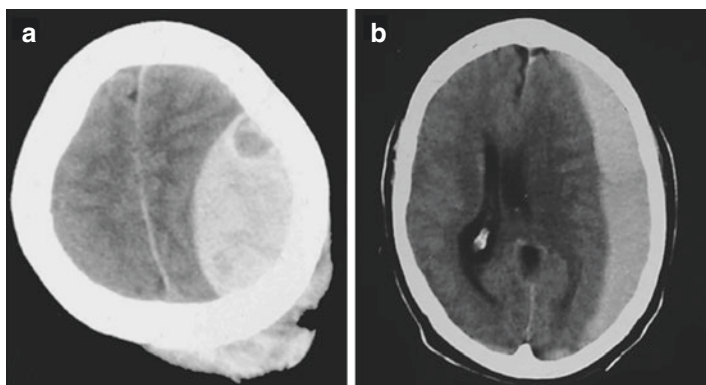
Non-contrast CT scan showing an acute epidural hematoma (with overlying scalp swelling) (a) and acute subdural hematoma (b)
